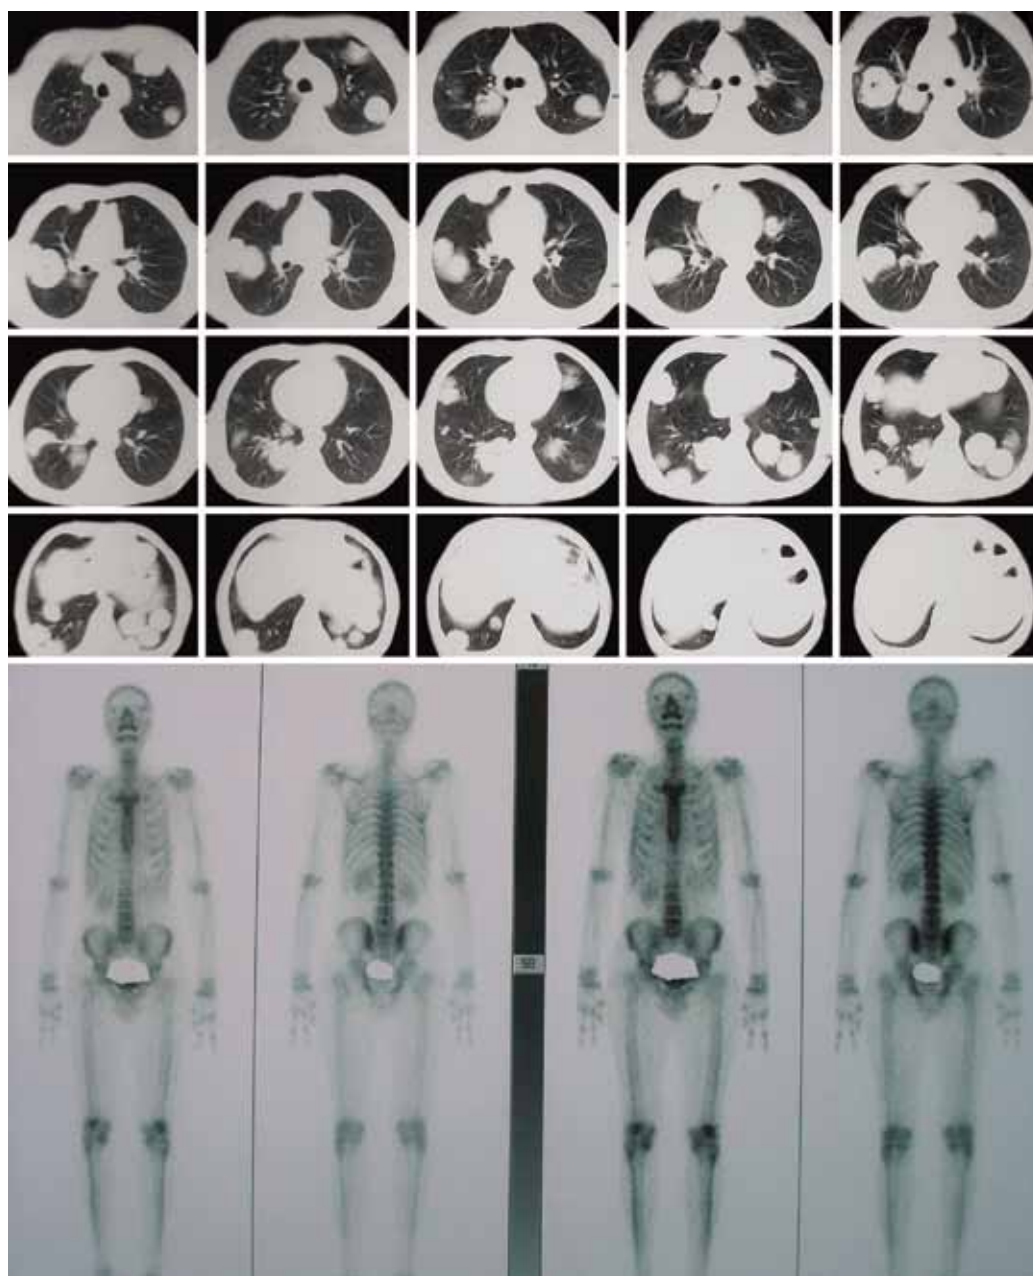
Pulmonary metastasis on contrast chest CT but no skeletal metastasis
